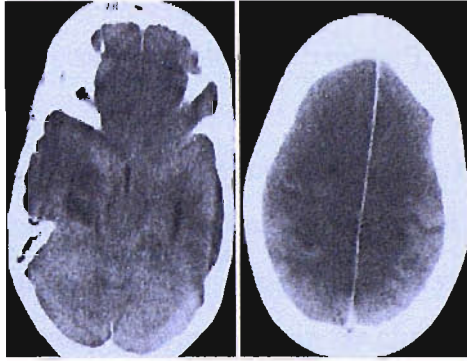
CT images demonstrating diffuse cerebral oedema. In the left-hand image the basal cisterns are effaced and the lateral ventricles compressed, whilst on the right there is a loss of definition between the gyri and sulci.
